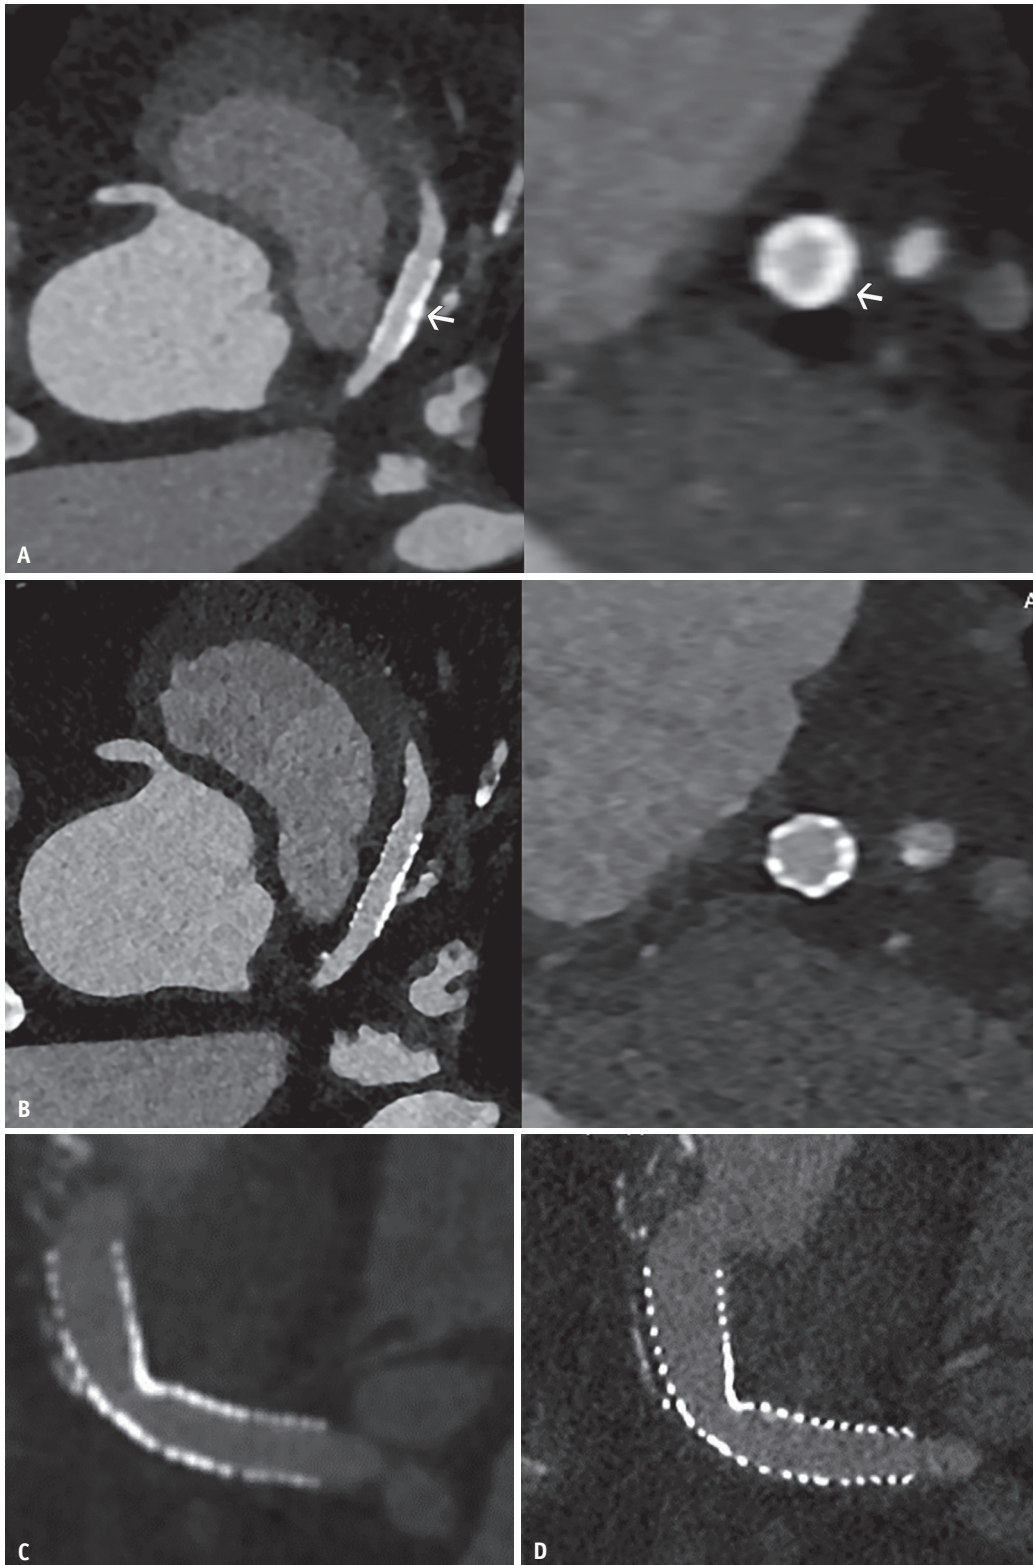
Improved evaluation of stents. A: Axial oblique (left) and short-axis (right) coronary CTA in a 64-year-old male from an EID-CT scanner shows a proximal left anterior descending coronary artery stent (arrows) with poor strut definition due to blooming artifact. B: Coronary CTA in the same patient from PCCT (left = oblique axial; right = short-axis) shows sharper stent definition, reduced blooming, and improved visualization of stent struts and lumen. C: Coronal oblique CTA in a 55-year-old female from EID-CT shows poor definition of a renal artery stent. D: Coronal oblique CTA in the same patient from PCCT shows sharper stent margins, reduced blooming, and improved luminal assessment. CTA = CT angiography, EID = energy-integrating detector, PCCT = photon-counting CT
